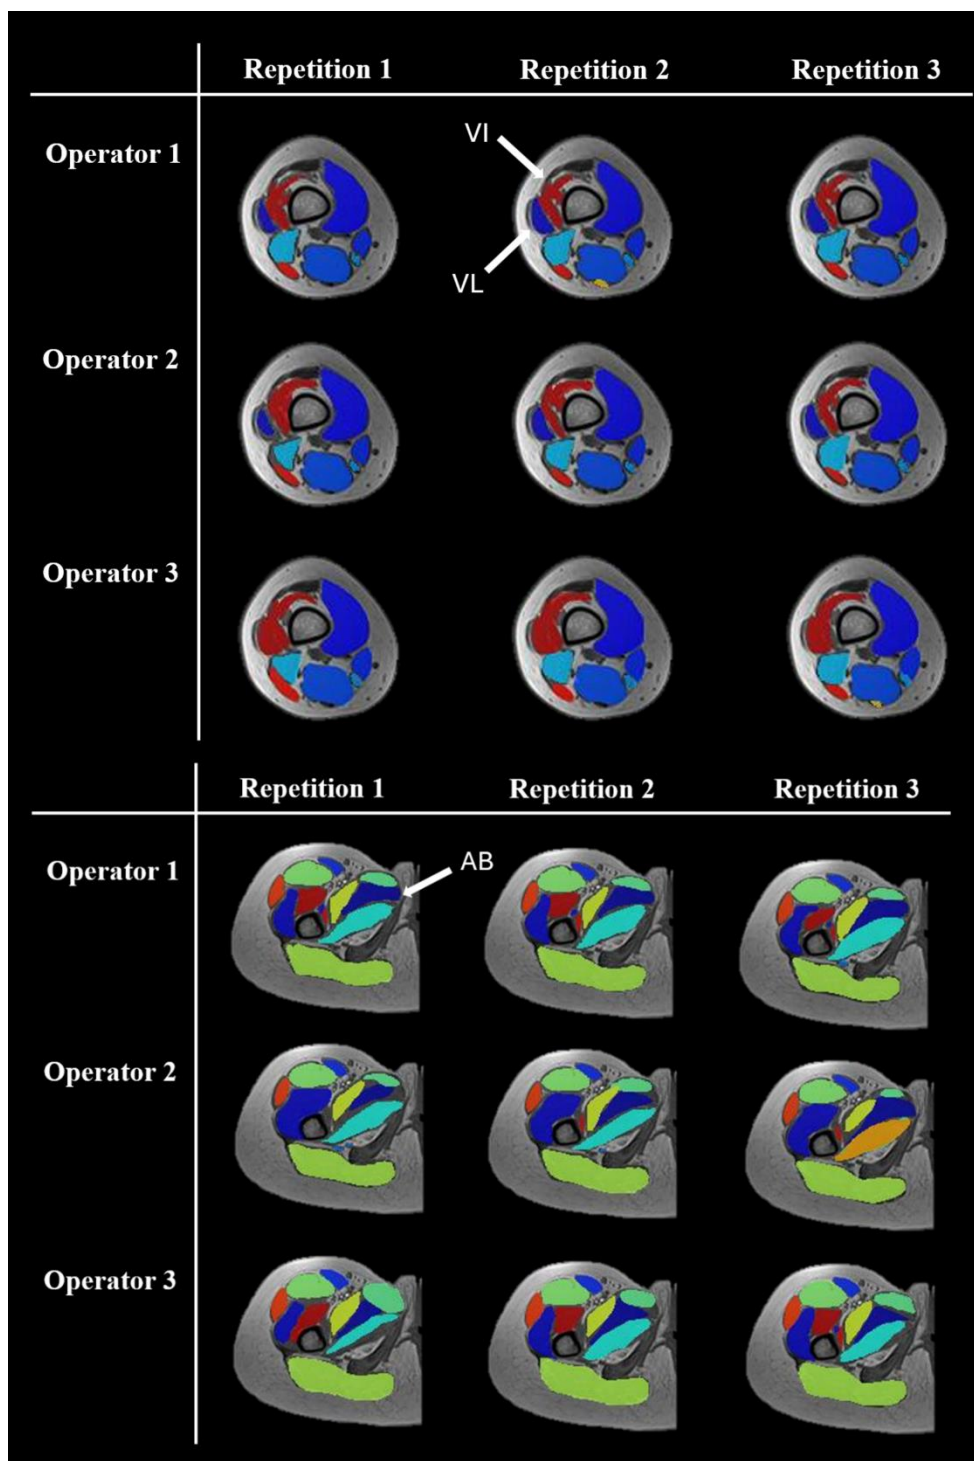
Visualization of manual segmentation cross 3 repetitions among 3 operators. The label combined MR images in the upper and lower sections are from the same subject selected for the repeatability analysis. Repetition 1-3 corresponds to the first through the last trial segments performed by the same operator.
